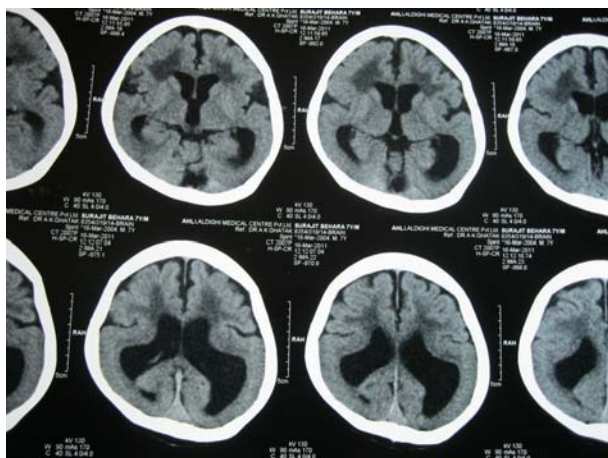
CT Scan of the younger brother
